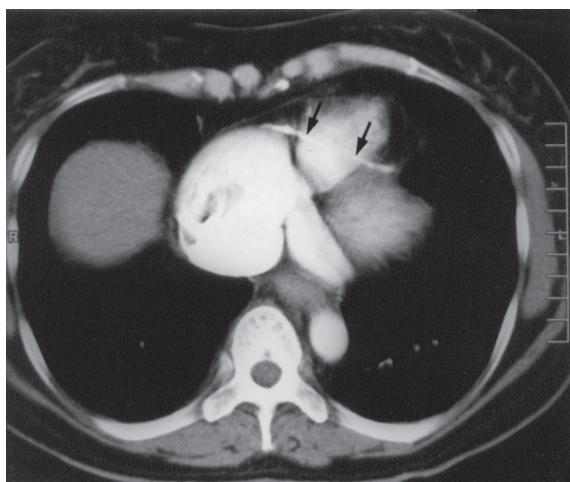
CT of thorax demonstrating the band of pericardial calcification (arrows) running across the cardiac surface and causing inward indentation of the left ventricular free wall.
